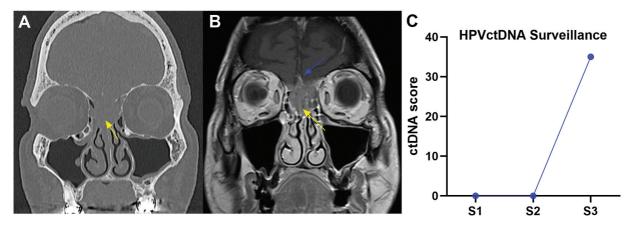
Coronal views of maxillofacial CT without contrast (A) and MRI T1 with contrast (B) demonstrate recurrent sinonasal neuroendocrine carcinoma (yellow arrows) arising from the olfactory cleft and involving the anterior skull base, with transdural involvement of cribriform/olfactory tract (blue arrow). NavDx tests (C) accurately captured the recurrence of the tumor, with elevated ctDNA in the third surveillance period. CT, computed topography; MRI, magnetic resonance imaging; ctDNA, circulating tumor DNA; S1/S2/S3, surveillance #'s 1, 2. and 3.
